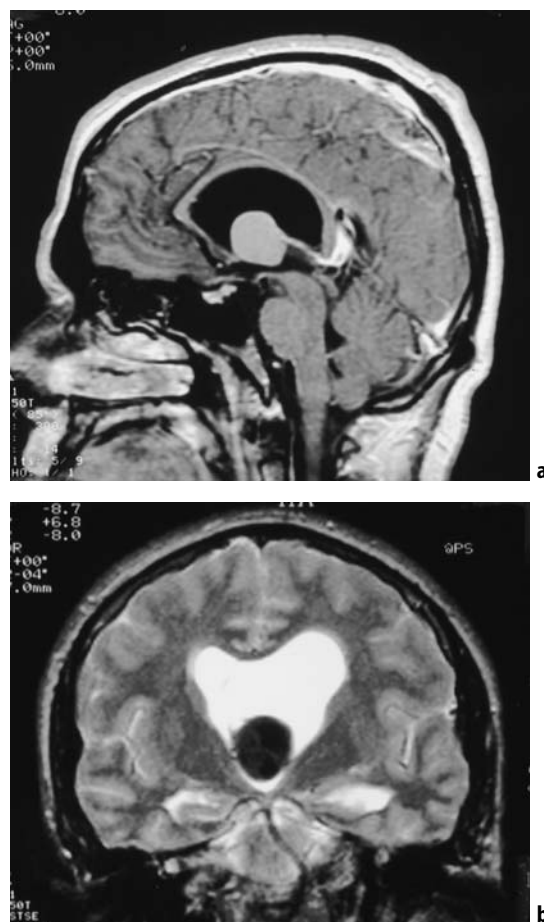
a–b MRI scan for severe intermittent headaches. a Sagittal T1 with a high-signal mass in the region of the foramen of Monro. b Coronal FSE T2, with a low-signal mass. The position and signal changes are characteristic of a colloid cyst.
